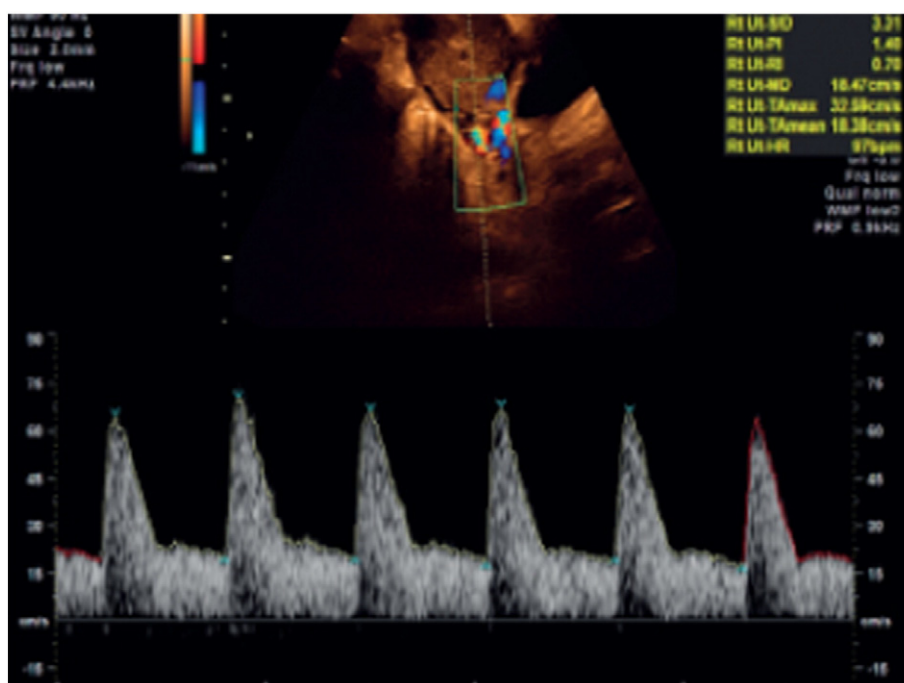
Typical first trimester uterine artery Doppler waveform [24].
